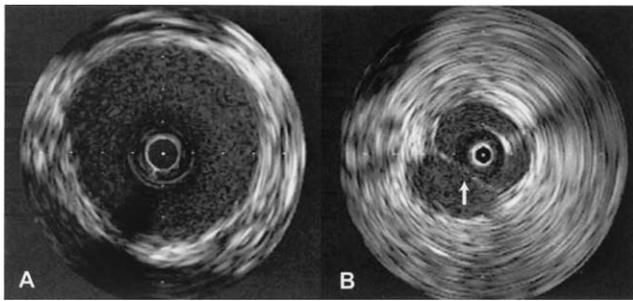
(A) Intravascular ultrasound (IVUS) of a normal renal artery. (B) IVUS demonstrating discrete, fixed, eccentric ridge.
